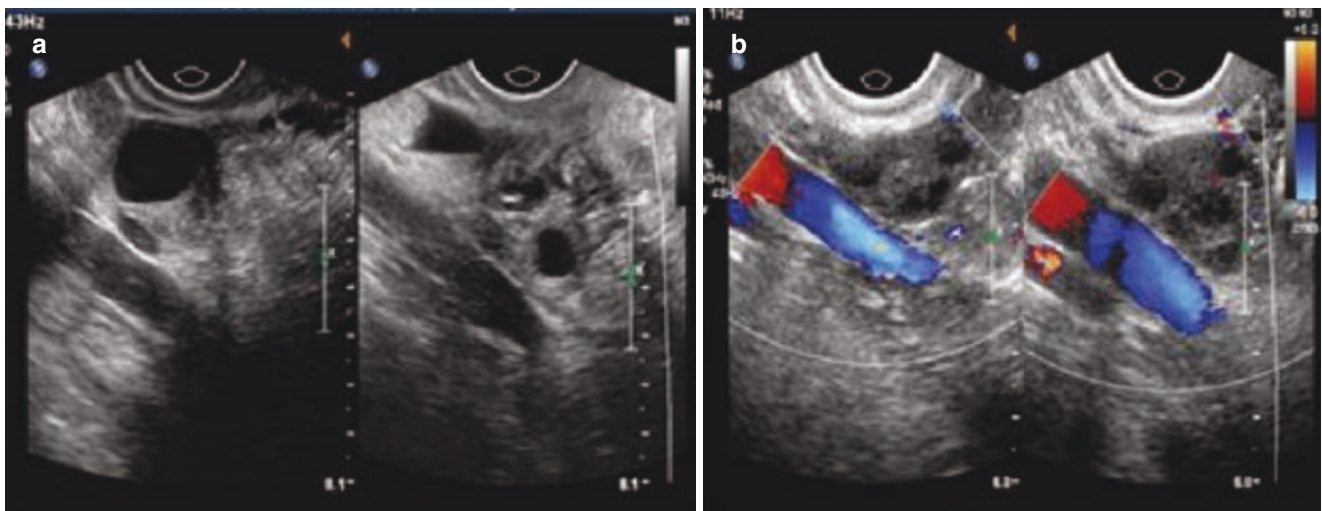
Relationship between ovary and internal iliac vessels. (a). 2-D images of the ovary and internal iliac vessels; (b). Color Doppler flow images of ovary and internal iliac vessels
